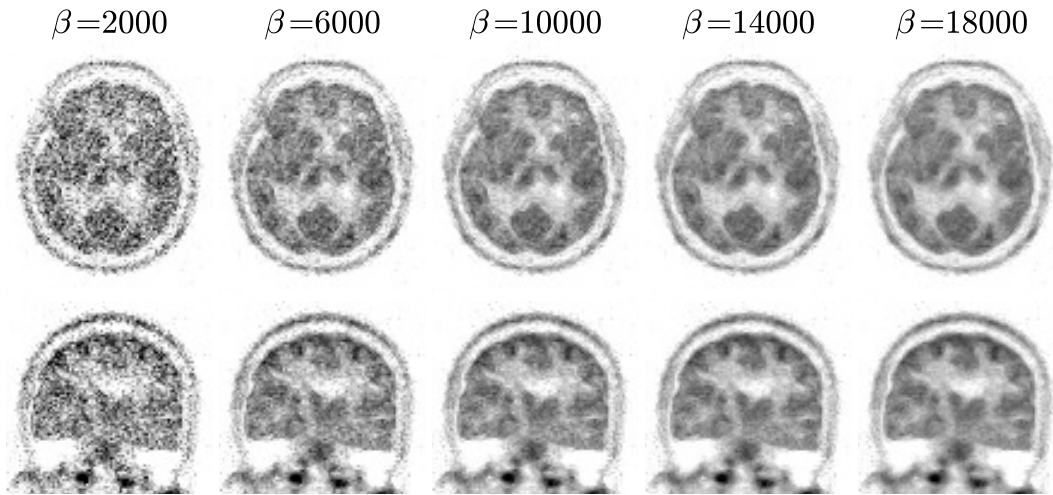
Real data FDG-guided MAPEM reconstructions as a function of β , using the same weights hyperparameters as were used in Figure 5.14. Noise levels decrease as β increases, without visually affecting the pattern of distribution of the radiotracer. © 2018 IEEE
